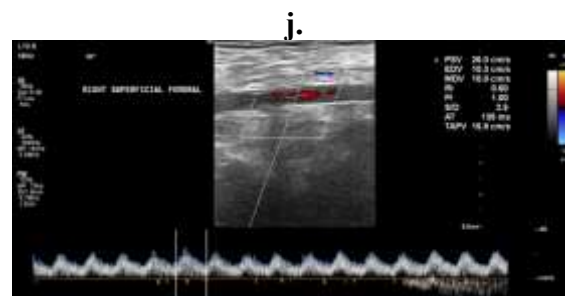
Image j. Color doppler and Spectral waveform of longitudinal section of right distal superficial femoral artery showing patchy color flow and low velocity monophasic waveforms. Echogenic content noted causing 60-70% stenosis- Partial thrombosis.
